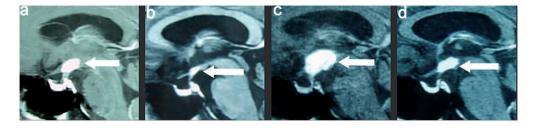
MRI imaging pre- and post-treatment. (a) Initial image taken before treatments. MRI revealed a mass in the hypothalamus. (b) Lesion size decreased post-HDMPT treatment. (c) Recurrence of the mass accrued because of the patient's spontaneous drug discontinuance. (d) Lesion size decreased again following HDMPT and AZP treatment.
